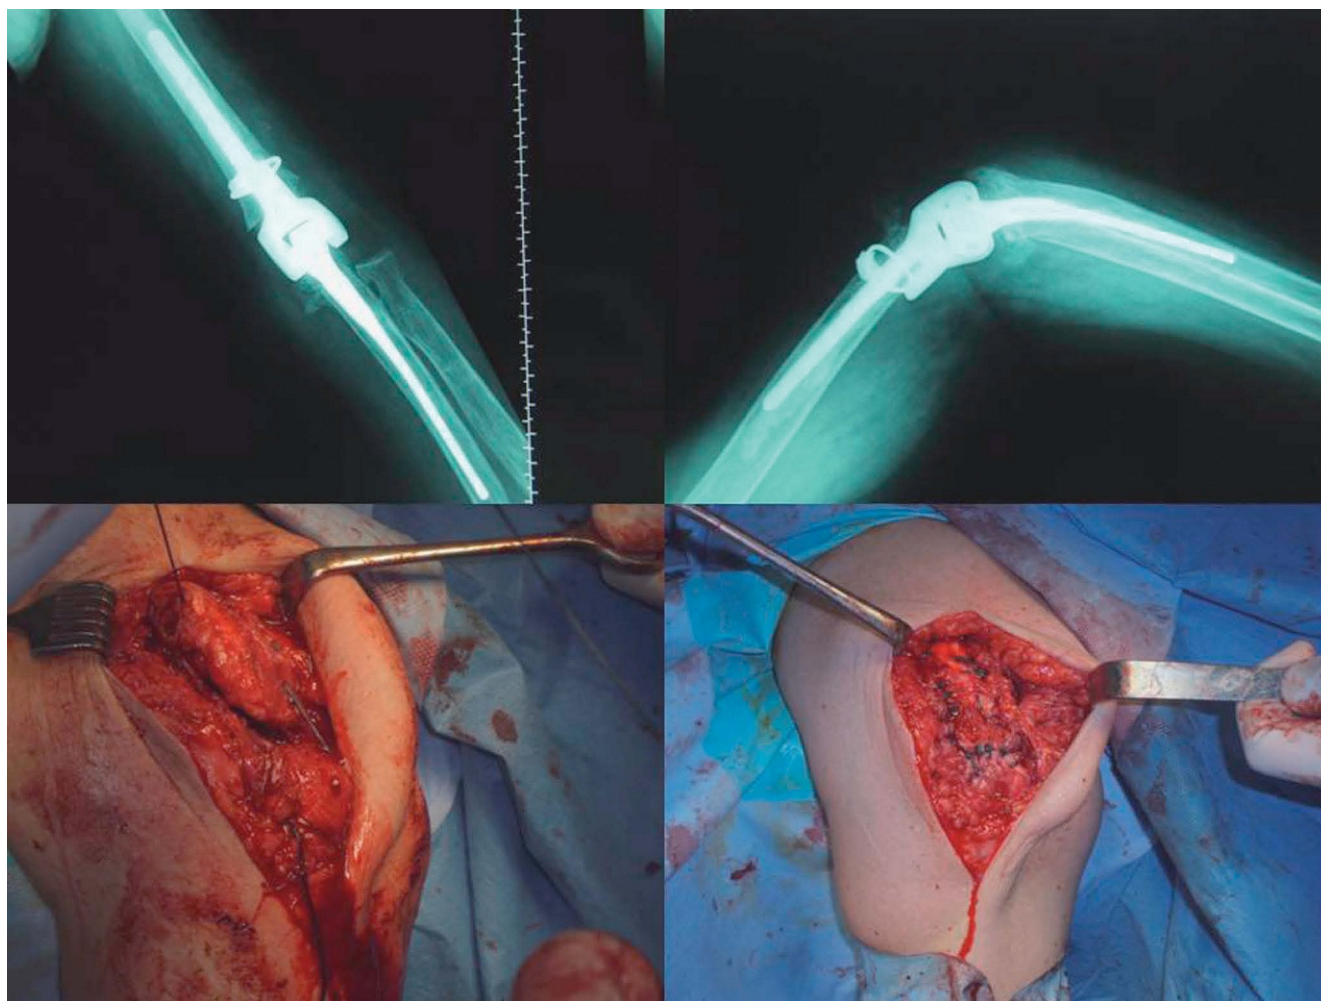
Image of the arthroplasty of the elbow. A) Radiographic guidance of the arthroplasty of the elbow. Heterotopic calcification can be seen in the dorsal region. B) Intra-operative image of the rupture of the distal tendon of the triceps sutured using a double Kracow and end-to-end sutures.
